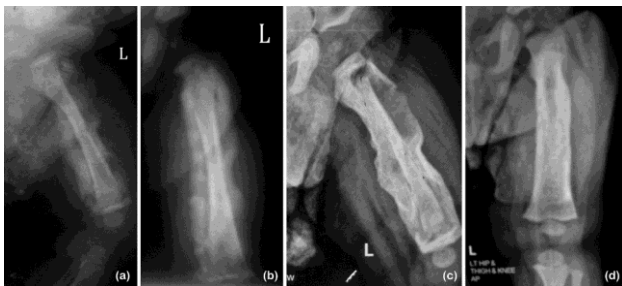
Radiographs of left femur. a) At 2 weeks showing solid periosteal reaction at distal end of femur. b) At 6 weeks showing solid periosteal reaction of entire femoral diaphysis. c) At 10 weeks showing sequestration of whole of femoral diaphysis surrounded by new bone (involucrum) giving it "Bone within Bone" appearance. d) At 16 weeks, partial re-sorption of sequestrum and remodelling of involucrum.
